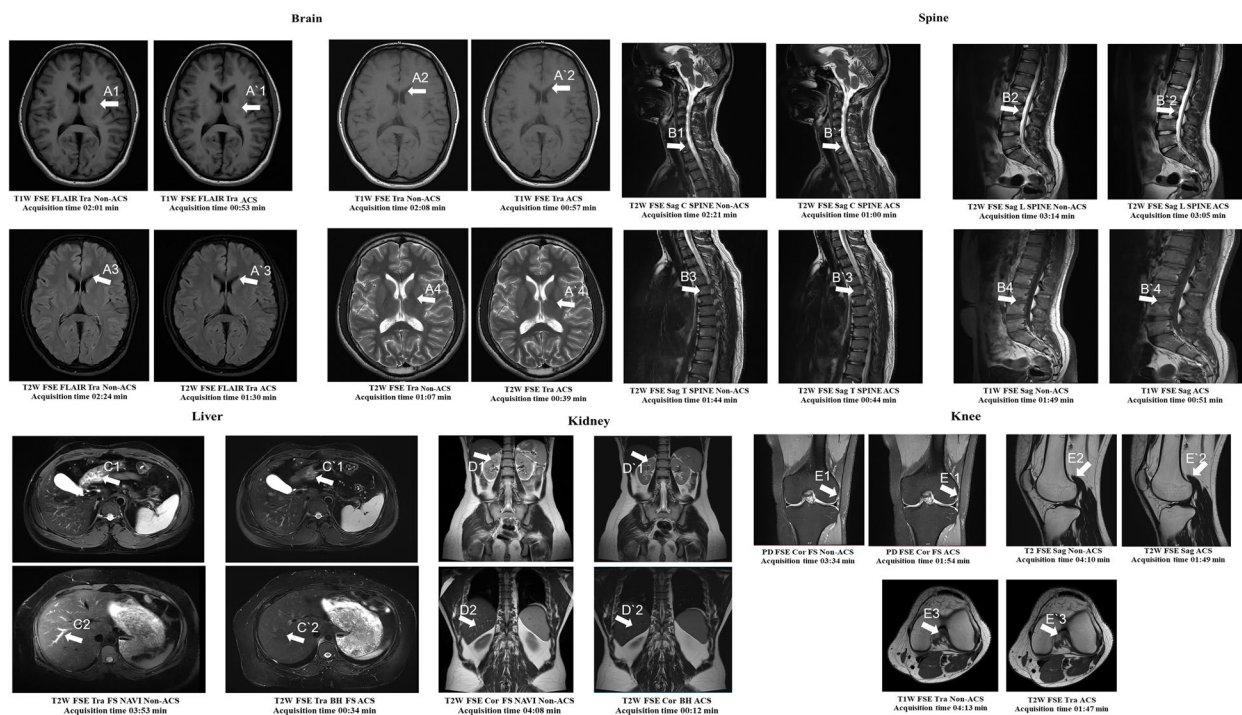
Example of MR images of brain, spine, liver, kidney and knee regions acquired with and without the ACS technique. Arrows A showcases T1W and T2W axial brain images. The arrows point to the boundaries of anatomical structures: thalamus (A1, A'1), lateral ventricles (A2, A'2, A3, A'3), and putamen (A4, A'4). The ACS images (A'1, A'2, A'3, A'4) provide more distinct and clearer structural boundaries than the non-ACS images. Arrows B displays T2W FSE sagittal spine images. In B1/B'1, the distinct features of the vertebral body in the C7 cervical spine appears much clearer in B'1. B2/B'2 highlights vertebral body of the L3 spine looking out for any clinically significant pathology, with B'2 offering more details. B3/B'3 reveals the vertebral body of the thoracic spine, with B'3 showing enhanced features. B4/B'4 focuses on the nucleus pulposus of the intervertebral disc, again with the ACS image (B'4) exhibiting better detailed features. Arrows C and D compare liver and kidney images respectively, indicating that ACS images exhibit superior fluid suppression, leading to better diagnostic clarity compared to non-ACS images (C and D). Section E depicts knee images. E1/E'1 shows lateral collateral ligament, with E'1 providing clearer details. Similarly, E2/E'2 and E3/E'3 demonstrate knee anatomical structures in sagittal and axial views, respectively, with ACS images offering superior quality and distinct detail
